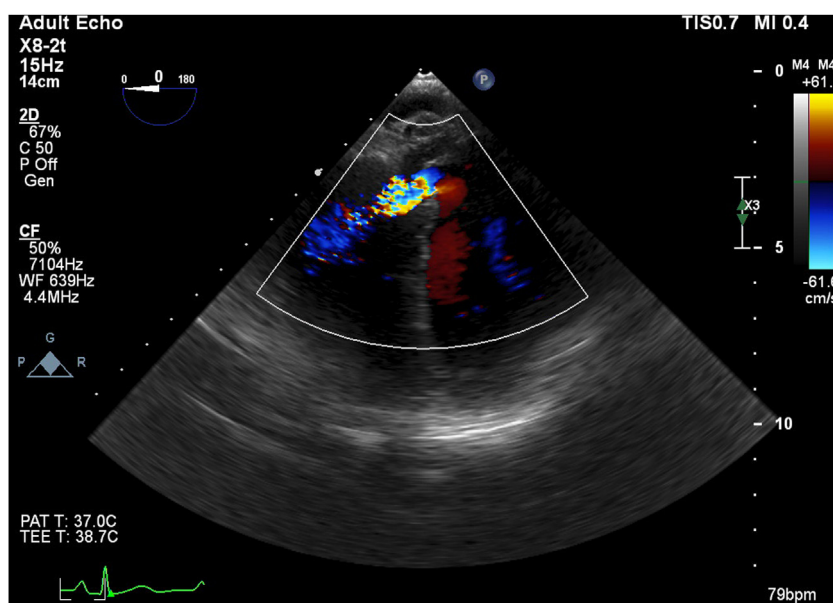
Transesophageal echocardiography revealed small to moderate size muscular ventricular septal defect with left to right flow.
